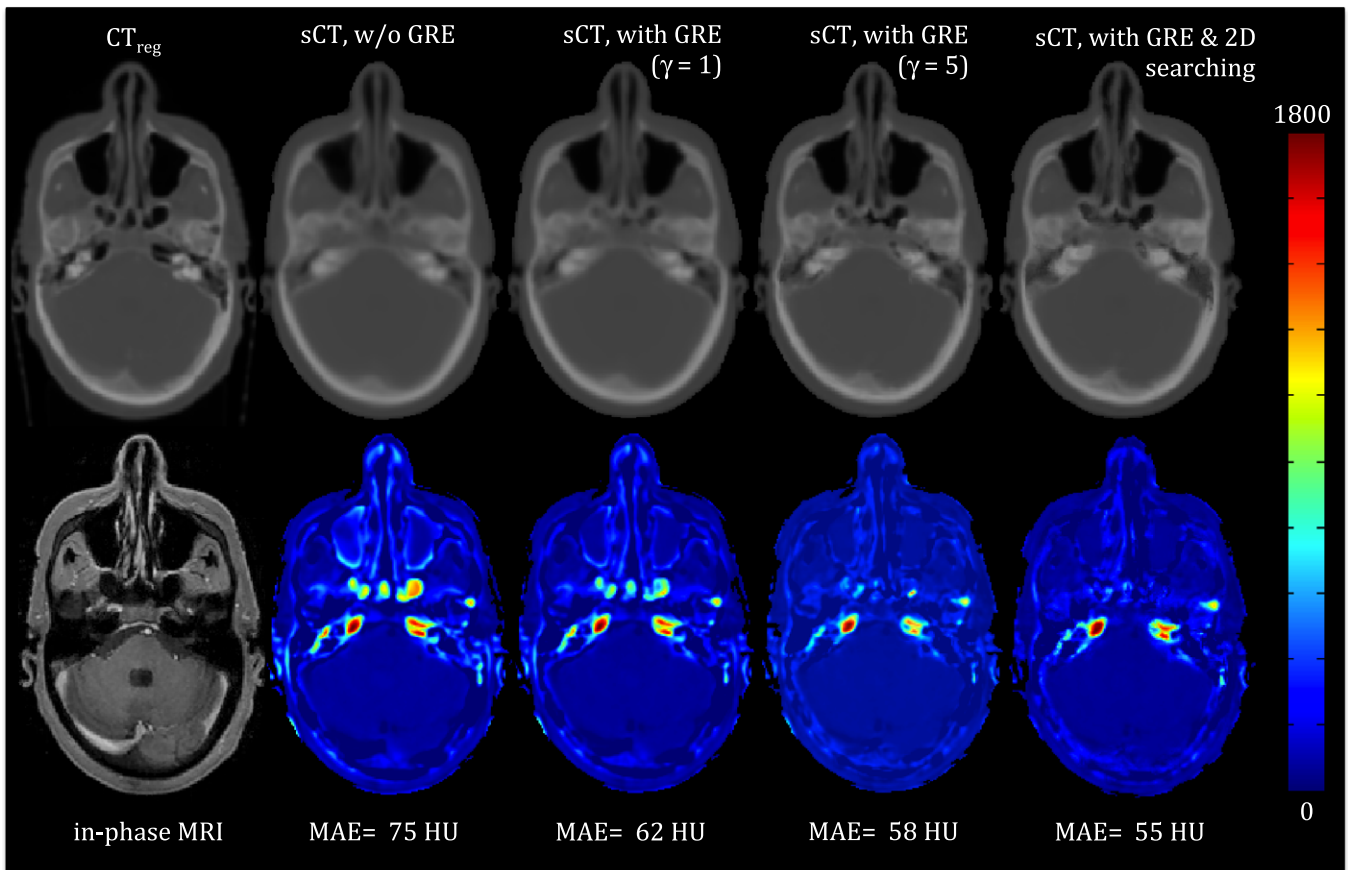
An example showing the impact of GRE, the power transform (γ) and 2-D neighborhood searching on the synthetic CT generation. The left panel shows the original CT and corresponding co-registered in-phase MRI. The second through fifth panels (left to right) are synthetic CTs (top) and color coded absolute difference maps (bottom) between the synthetic CT and the original CT without GRE, with GRE but without 2-D searching and $\gamma = 1$ and $\gamma = 5$, respectively, and with GRE ($\gamma = 5$) and 2-D searching. The mean absolute error of each difference map is also noted. [Color figure can be viewed at wileyonlinelibrary.com]
